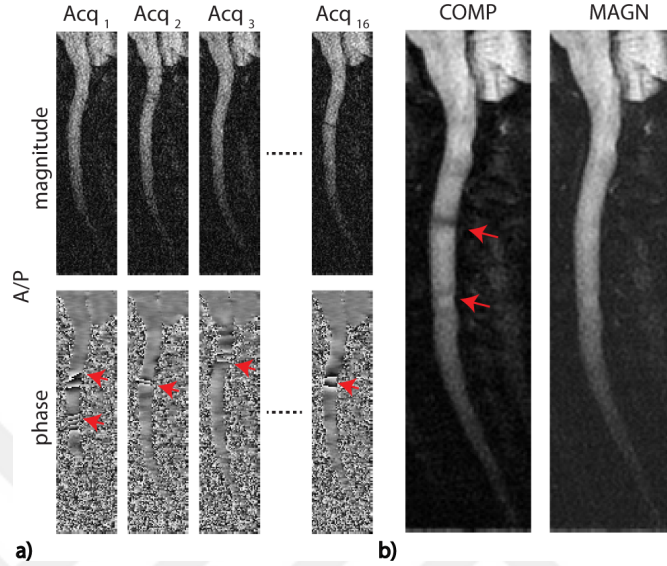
Local phase problems in DWI of the cervical spinal cord. a) Magnitude and phase of each acquisition for a single slice, following a refocusing reconstruction to correct for global phase errors and a partial k-space reconstruction. Local phase errors (shown by red arrows) are especially prominent in the case where diffusion sensitizing gradients are in the A/P direction, as in this example. b) When direct complex averaged, the phase errors result in local signal cancellations. Magnitude averaging, on the other hand, leads to an accumulation of noise especially in regions that were SNR-starved prior to averaging.
